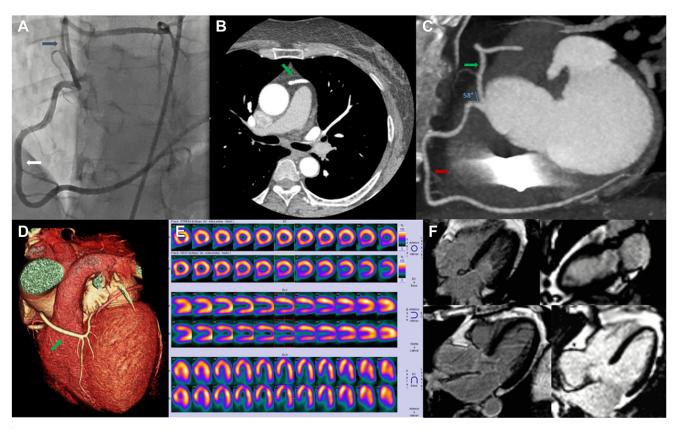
A: Coronary angiography demonstrated the common origin of the LMCA (blue arrow) and the RCA (white arrow) from the right coronary sinus. B: Contrasted chest CT. The prepulmonary course of the LMCA is seen (green arrow). C: CT coronary angiogram. Coronal view of the heart showing the anomalous origin of the LMCA (green arrow) from the right coronary sinus. The RCA (red arrow) also originates from the same coronary sinus. The 58° birth angle, the oval morphology of the ostium and the absence of an intramural course can be seen. D: Cardiac volumetric reconstruction. Demonstrates the absence of interarterial course (between the aorta and pulmonary artery) of the LMCA. E: Myocardial perfusion test negative for ischemia. F: Cardiac magnetic resonance imaging. Absence of late gadolinium enhancement in 4-, 2-, 3- and 5-chamber views. CT = computed tomography; LMCA = left main coronary artery; RCA = right coronary artery.
